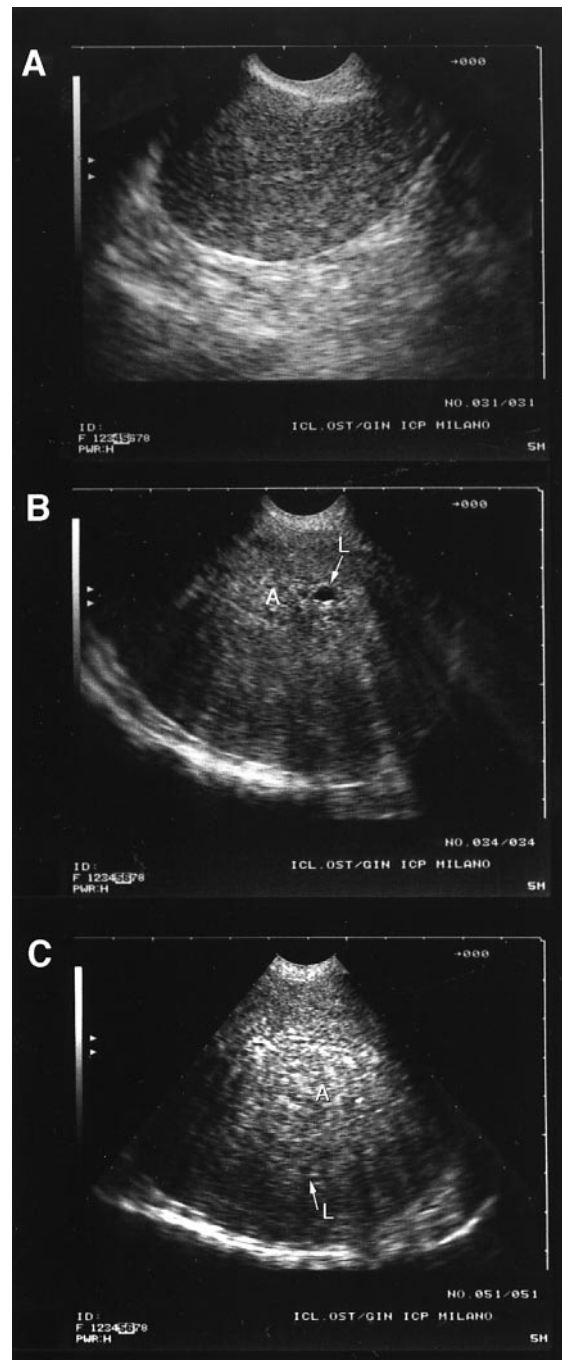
(A) Ultrasonographic pattern of a normal uterus in a longitudinal scan obtained with a transvaginal probe. The anterior and posterior walls show homogeneous myometrium without areas of distorted echotexture. (B) Ultrasonographic pattern of mild diffuse adenomyosis (A) in a longitudinal scan obtained with a transvaginal probe. An indistinctly marginated heterogeneous myometrial area with distorted echotexture and a circumscribed anechoic lacuna (L) are localized within the inner portion of the uterine wall. (C) Ultrasound pattern of severe diffuse adenomyosis (A) in a longitudinal scan obtained with a transvaginal probe. The thickened posterior uterine wall consists of indistinctly marginated heterogeneous myometrial tissue with distorted echotexture. A typical circumscribed anechoic lacuna (L) is observed and asymmetry between the anterior and posterior uterine walls is evident.
